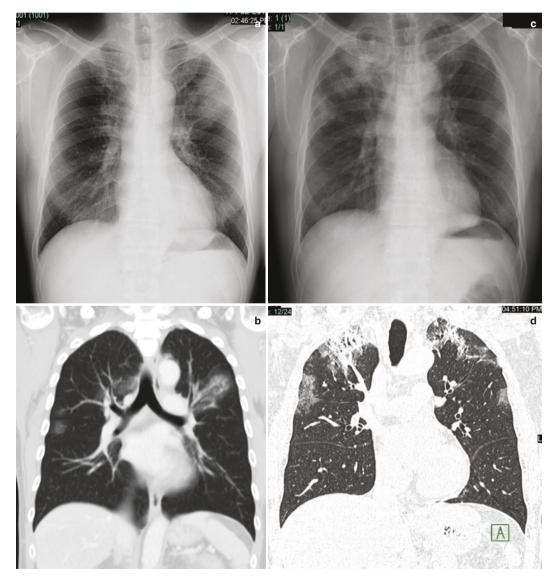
A 69-year-old man with asthma and chronic eosinophilic pneumonia. (a) Initial chest radiograph shows a peripheral opacity in the left upper zone. (b) Coronal CT image reveals bilateral upper lung peripheral ground-glass opacities. (c) Follow-up
